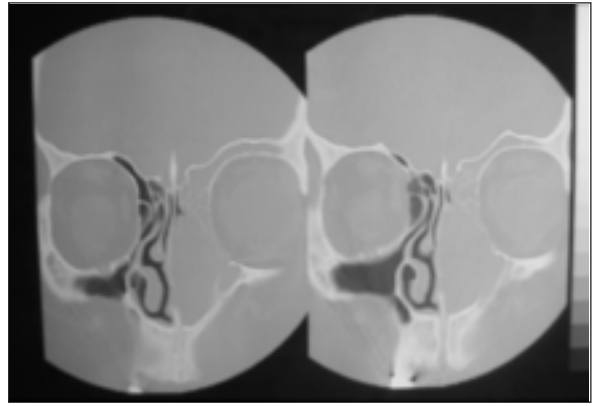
Computed tomography image showing soft tissue density in the right nasal cavity and sinuses.
